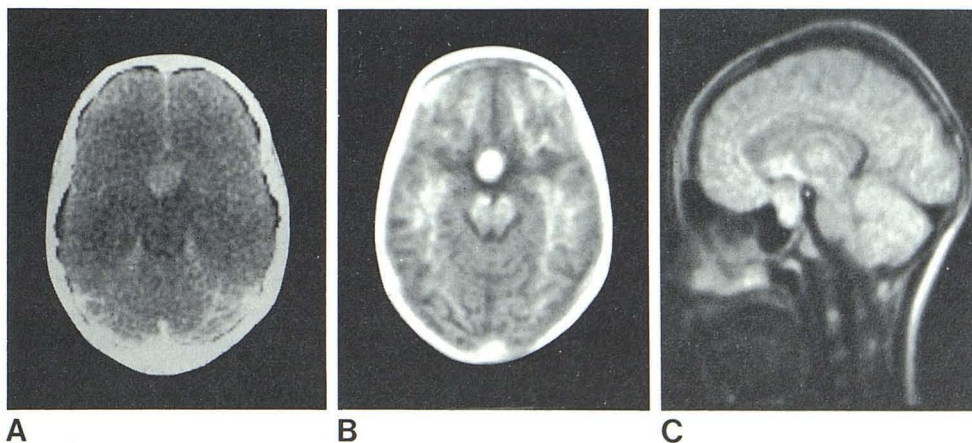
Epidermoid tumor. A, Contrast-enhanced CT scan. B, IR<sub>1400/400</sub>. C, Sagittal SE<sub>1080/40</sub>.
